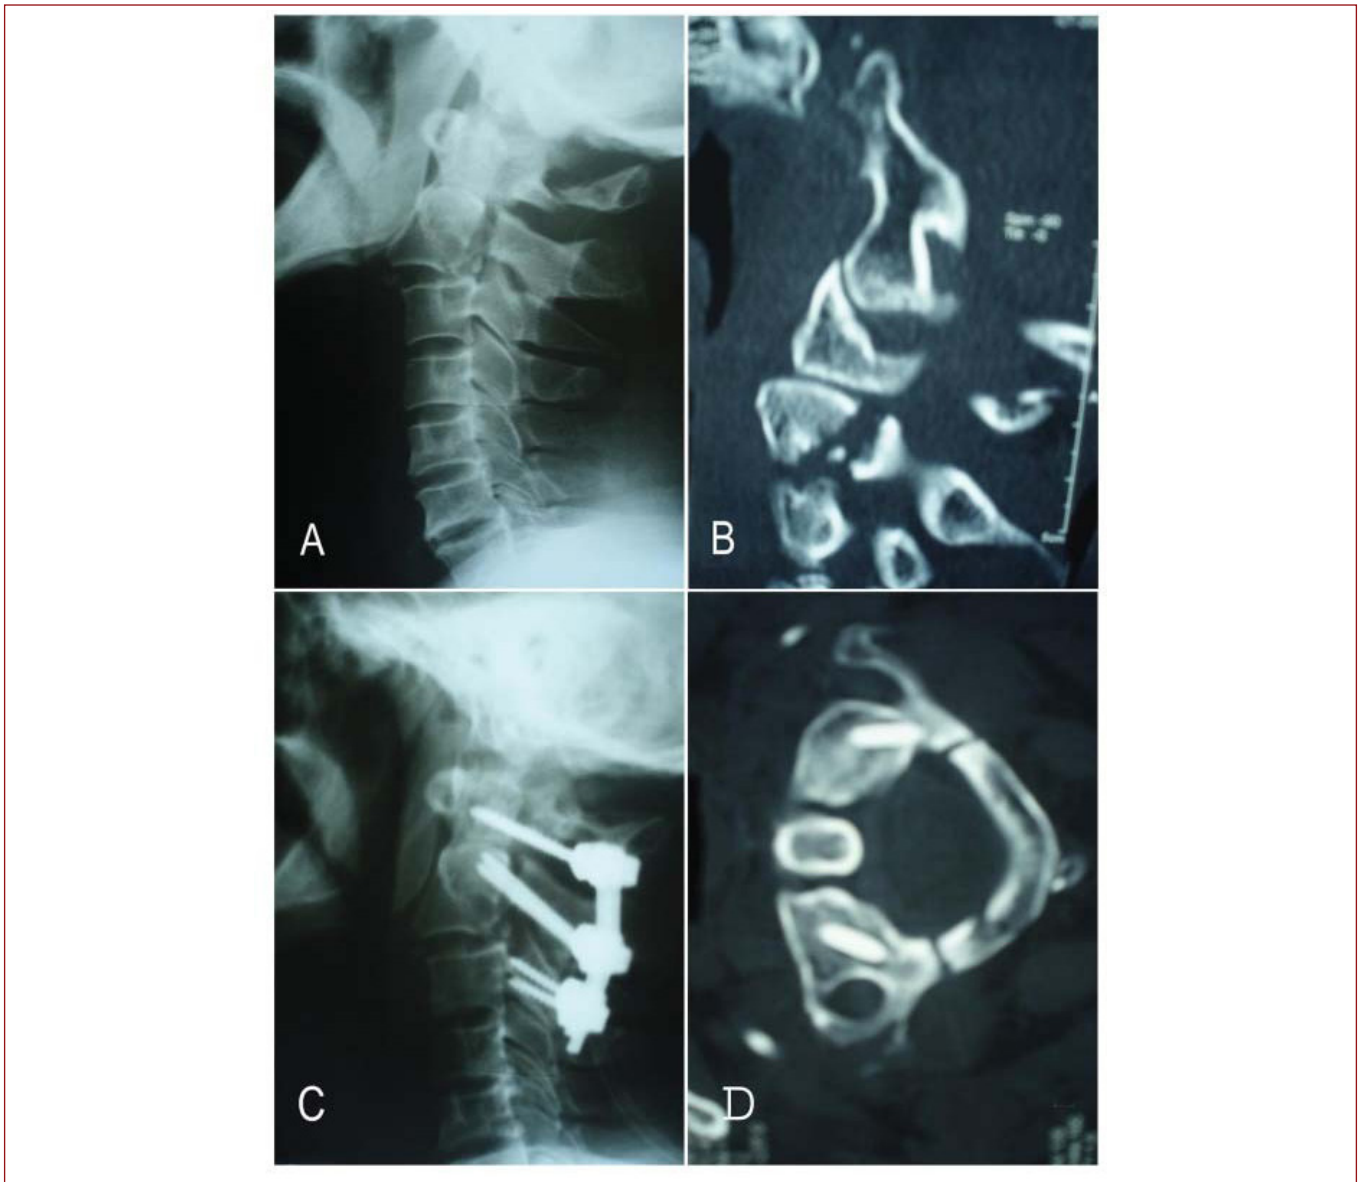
a. Preoperative lateral cervical X-ray, b. Preoperative reconstructed computerized tomography c. Postoperative lateral cervical X-ray, d. Postoperative axial cervical computerized tomography of a male patient aged 57 with a type 2 odontoid fracture.
